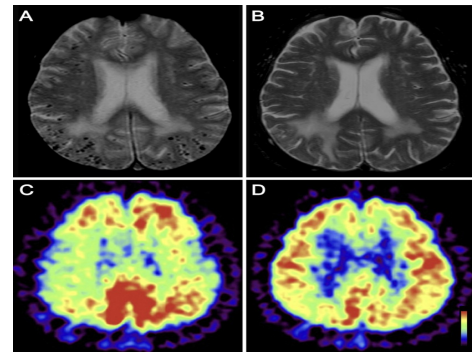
MRI and PET images showing brain abnormalities associated with AD.
